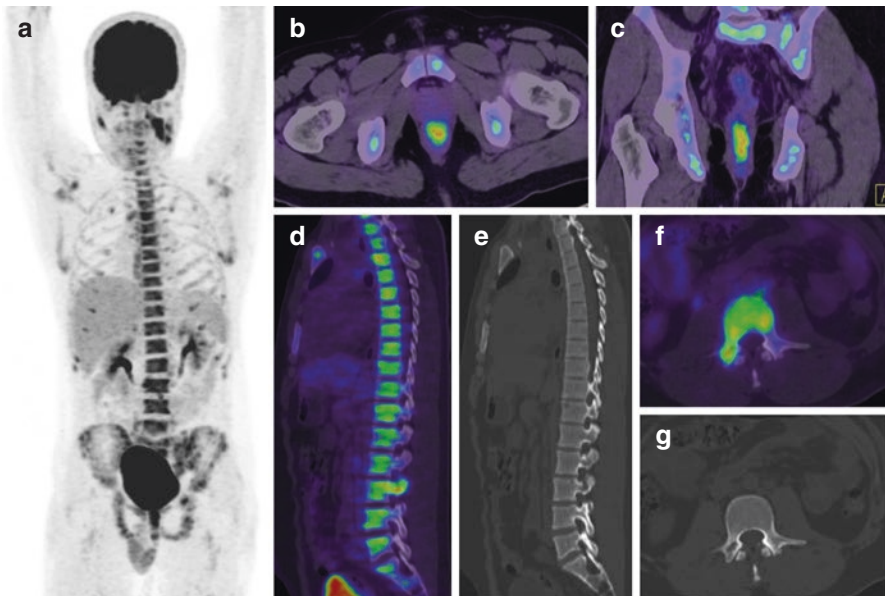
A 28-year-old gentleman diagnosed with primary adenocarcinoma of the rectum, ¹⁸F-FDG PET/CT (a - MIP) for initial staging showed intense FDG avid lesion in rectum (b - axial fused PET/CT, c - coronal fused PET/CT) with diffuse intense heterogeneous FDG uptake in the marrow (d - sagittal fused PET/CT, e - sagittal CT section in bone window). Heterogeneous FDG uptake in the marrow with involvement of the right pedicle of L3 vertebra (f, g), a bone marrow biopsy was done which confirmed marrow metastases from poorly differentiated adenocarcinoma
